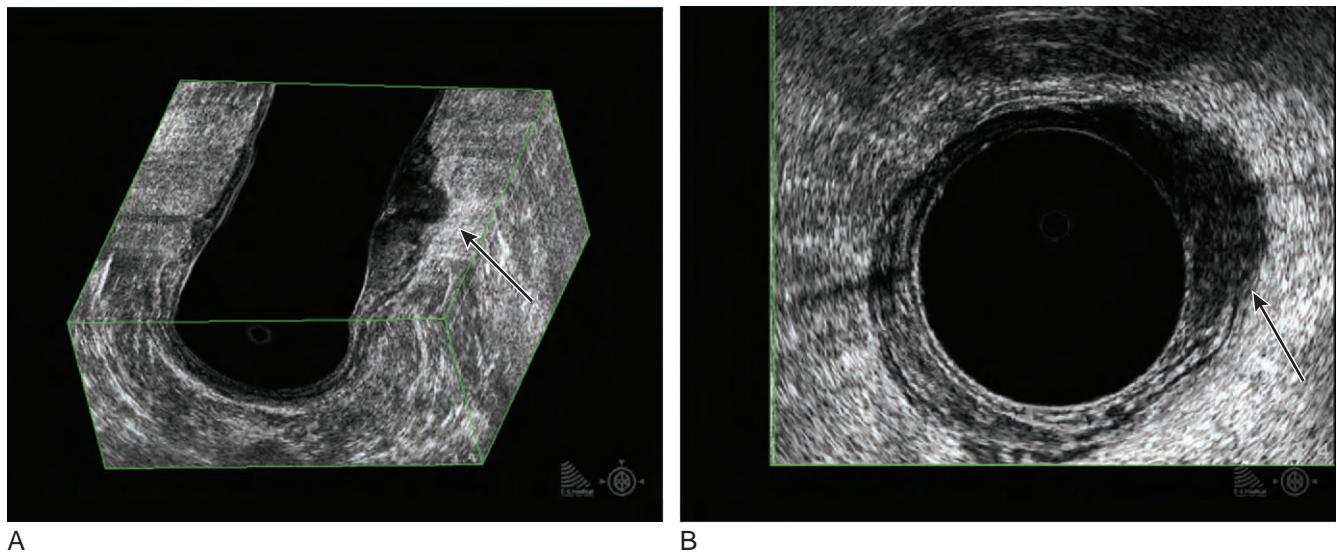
A and B, Endorectal ultrasound showing stage T3 rectal cancer (*arrows*). (Courtesy of B-K Medical, Herlev, Denmark.)
